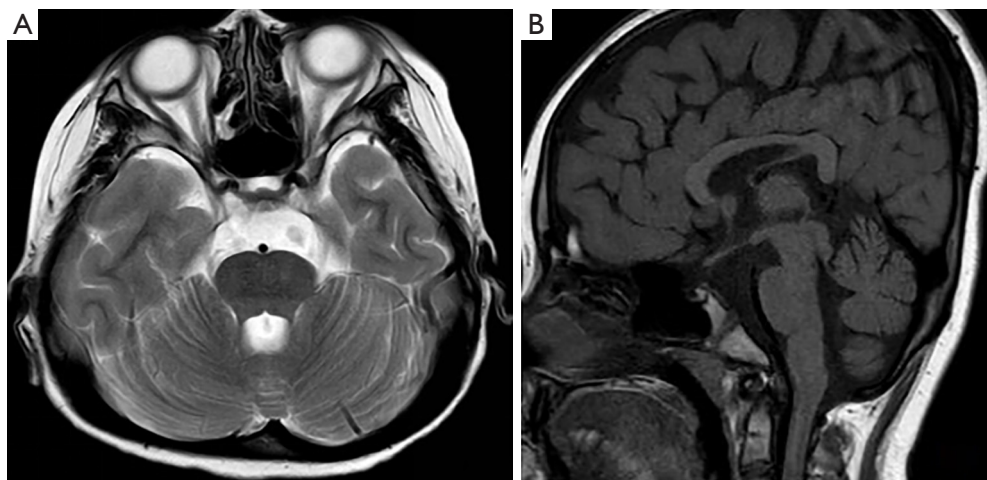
MRI images. (A) Enlarged anterior pontine cistern; (B) hypoplasia of corpus callosum and pituitary gland.
